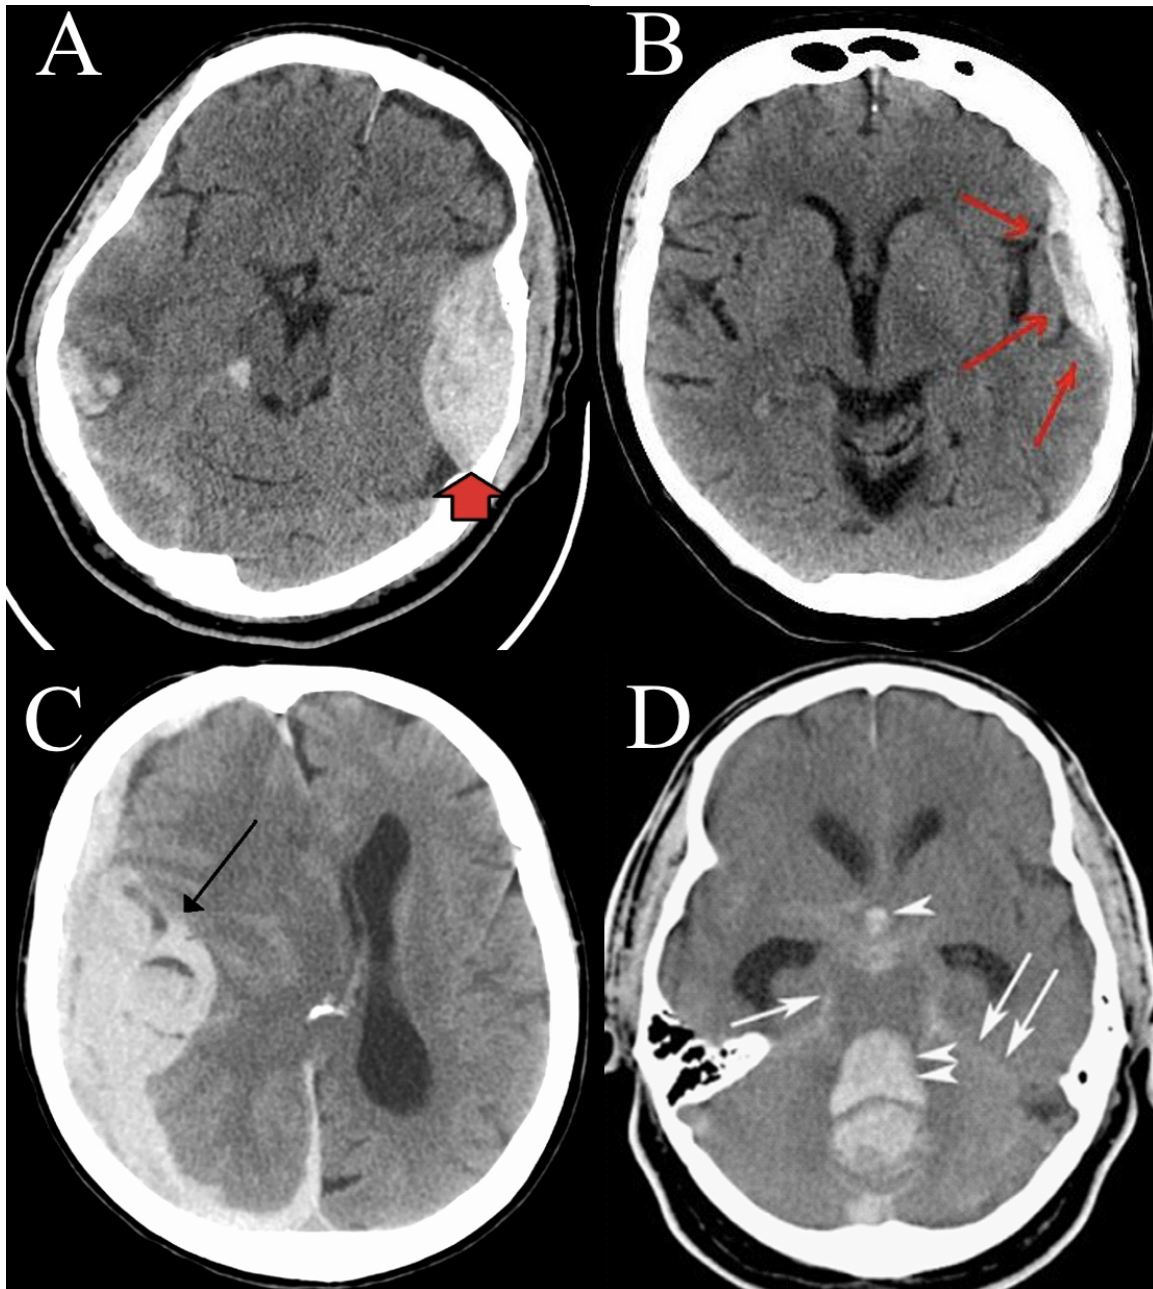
Different types of cranial hematomas on CT head.
